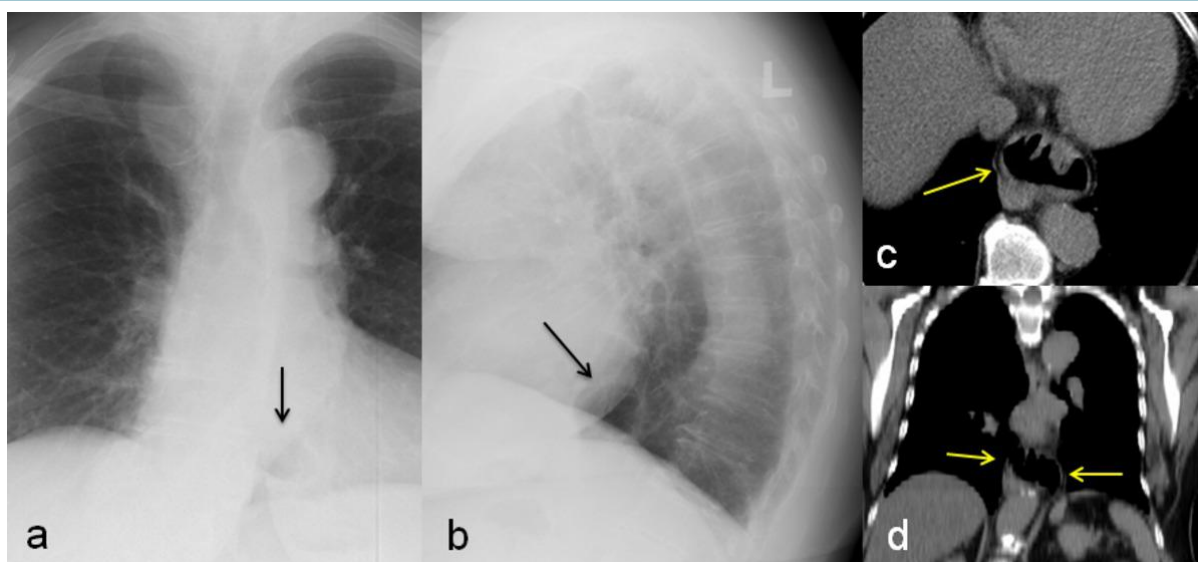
Frontal (a) and lateral (b) chest X-ray in a 77-year-old woman showing a radiolucency area in the lower middle mediastinum. CT scan (c) and coronal MPR reconstruction (d) demonstrate that the radiographic finding is consistent with a hiatal hernia (arrows).
